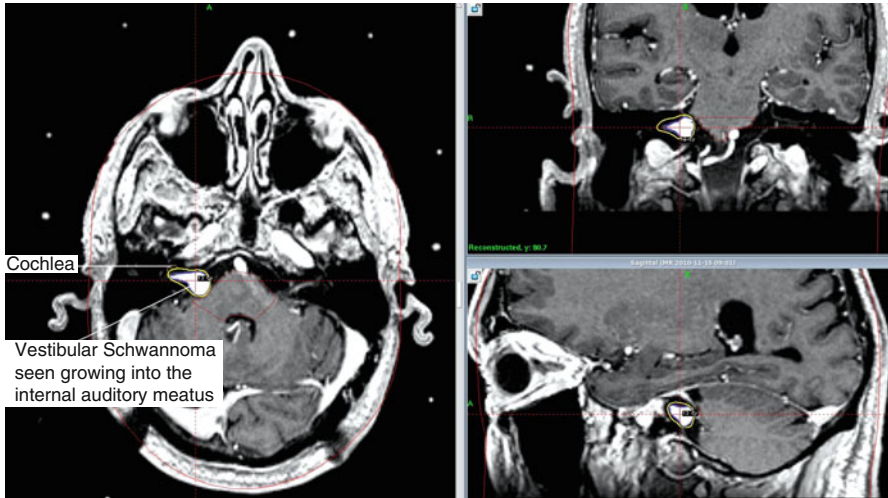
Vestibular schwannoma contoured on T1 gadolinium-enhanced MRI sequence
